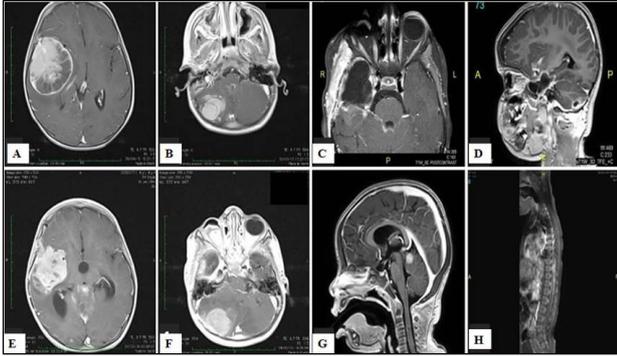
(a) contrast enhanced t1-weighted MR images. A mass at the frontotemporal region with strongly enhanced. (b) Axial section at the level of cerebellar hemispheres shows a strongly enhanced mass located at the right cerebellar hemisphere. (c and d) no lesion was detected on the first month postoperative contrast enhanced t1- weighted MR sequences. (e, f, g and h) tumor recurrence at operation field and new strongly enhanced focuses, one is at the superior part of the vermis, one is at the gyrus rectus and the other is in the spinal cord at the thoracic 12th level.
